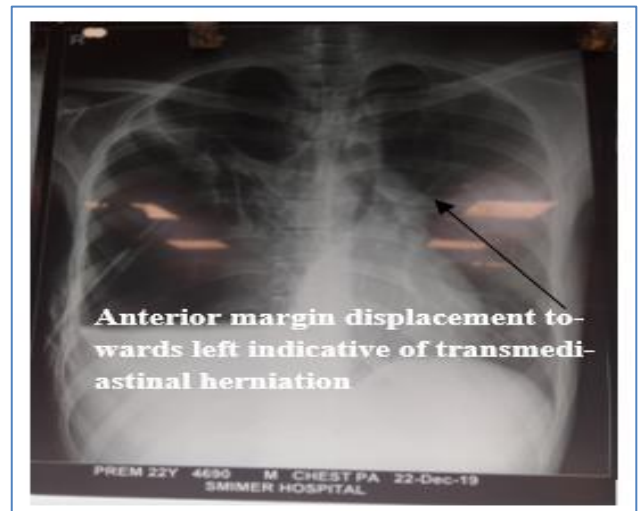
Chest X-ray comparative with CT scan.
